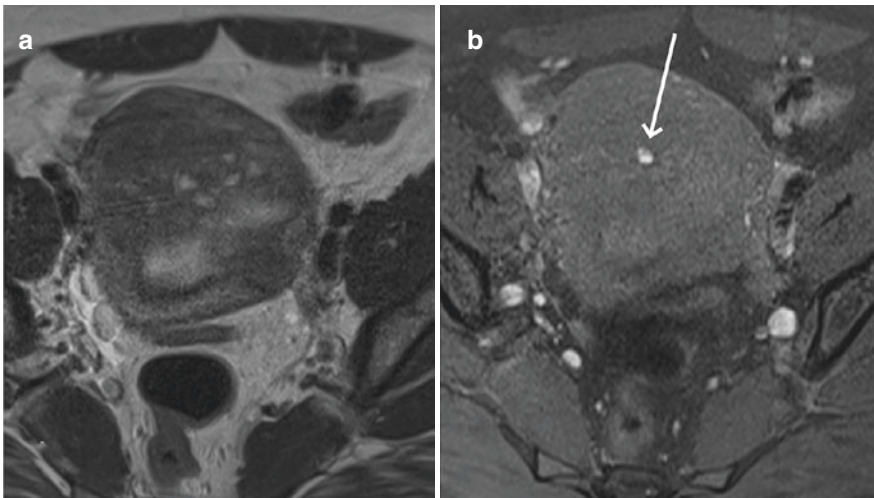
Differences of T2W and T1W MRI in adenomyosis. Axial images of the same uterus in 42-year-old woman. (a) T2W sequence, showing several high-intensity signal islets. (b) T1W with fat suppression: only one of the ectopic areas as seen on a is hemorrhagic (arrow)
